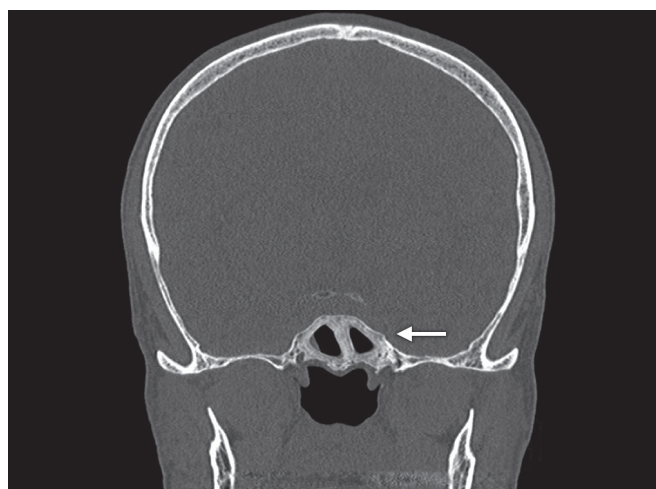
Coronal CT in the bone window demonstrating osteitis involving >50% of the sphenoid sinus walls (arrow).
